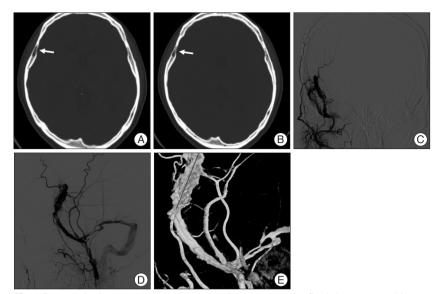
Preoperative images showing intraosseous dural arteriovenous fistula in a 46-year-old woman. Bone window of brain CT images (A and B) revealing prominent diploic space on the right parietal bone and small defect on inner table along the middle meningeal artery (MMA) groove (white arrows). Right external carotid angiograms, anteroposterior view (C) and lateral view (D), demonstrate a dilated fistulous venous pouch within the basal portion of right parietal bone, which is fed by frontal branch of the right MMA, drains into transverse sigmoid sinus junction through dilated middle meningeal vein. The intraosseous fistulous venous pouch is measured 29×9 mm on 3D rotational angiogram (E).
